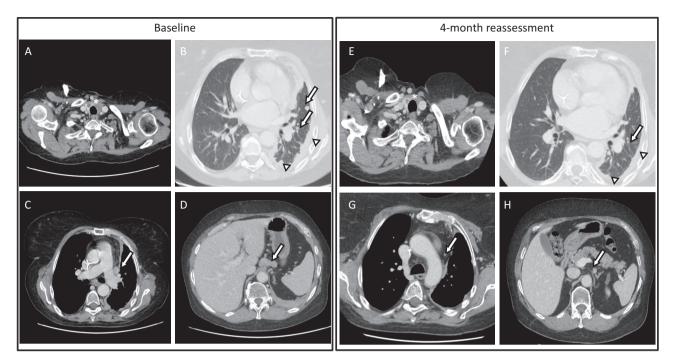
CT-scan with contrast performed before (A-B-C-D) and after 4 months of entrectinib (E-F-G-H). In (A) and (E), residual thyroid tissue is highlighted with an asterisk; in (B) and (F), arrows and arrowheads point to lung and subpleural nodules and thickenings, respectively; in (C) and (G), an arrow points to a mediastinal node; in (D) and (H), an arrow points to an abdominal lymph node cluster.
